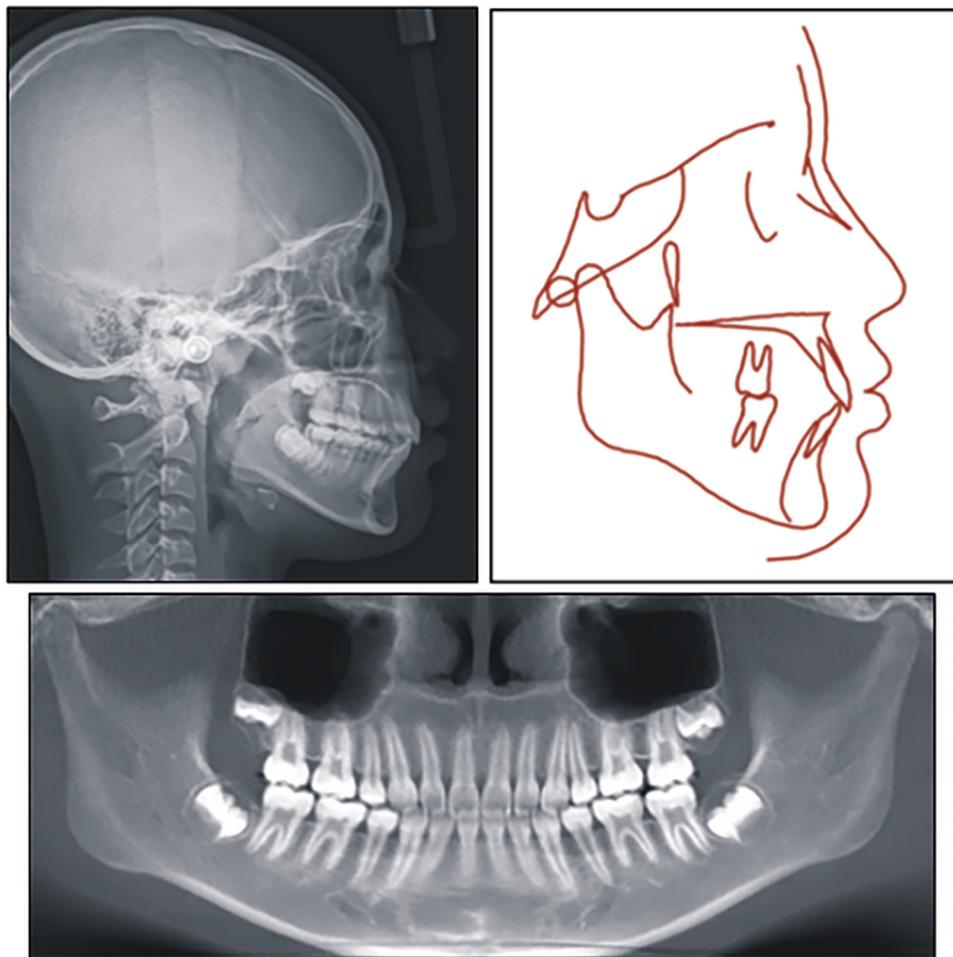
Posttreatment cephalogram, tracing, and panoramic radiograph.
